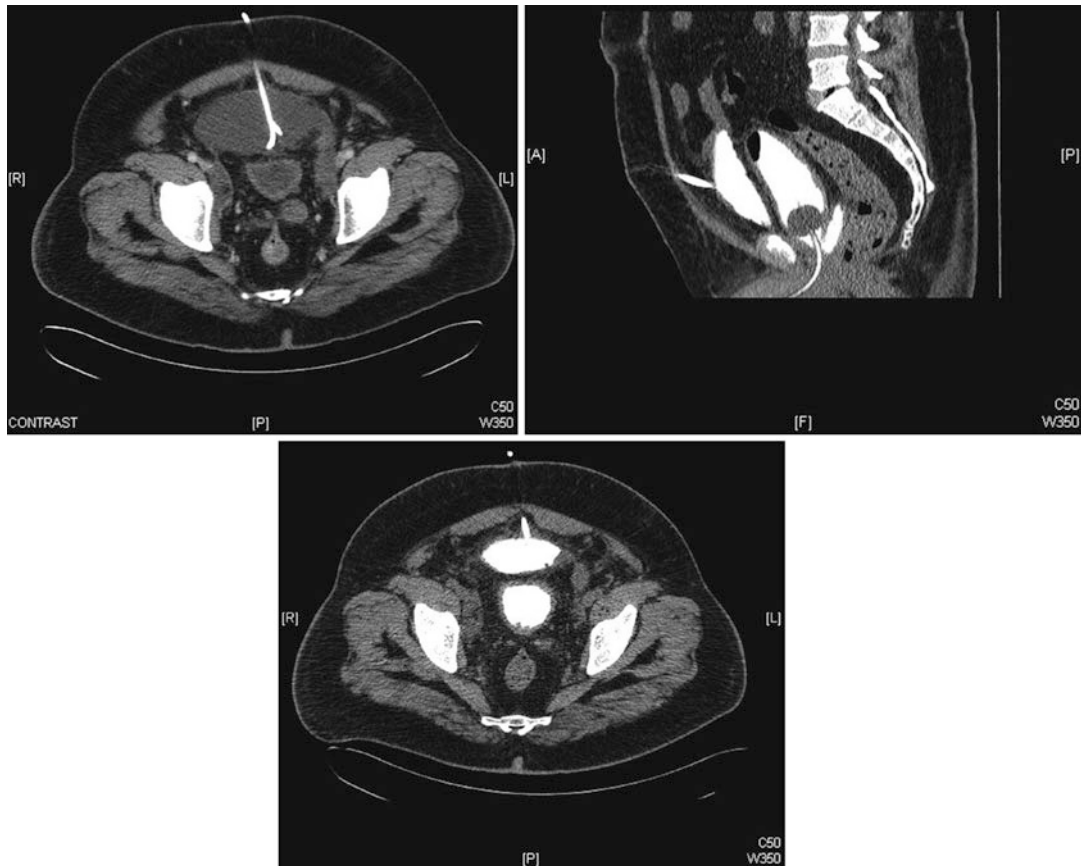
(a) Noncontrast CT scan revealing drain placement. (b) Sagittal image revealing the bladder with a Foley catheter in the bladder and the drain in the collection. (c) Cross-sectional view
